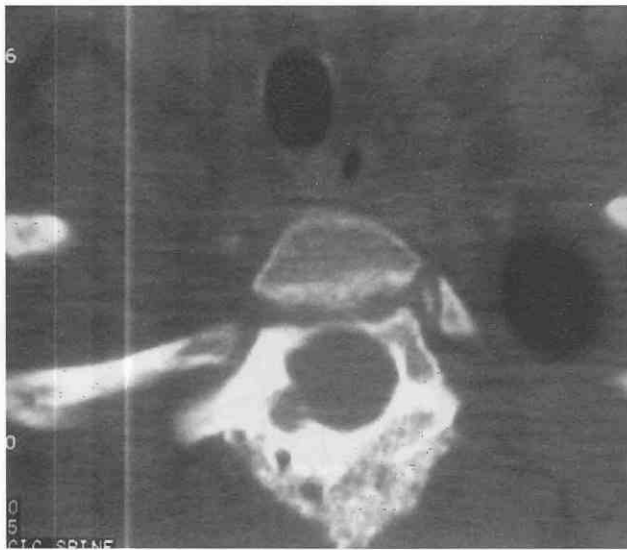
Axial CT image showing a lucency of the lamina of T1 with surrounding sclerosis, which proved to be an osteoid osteoma.
